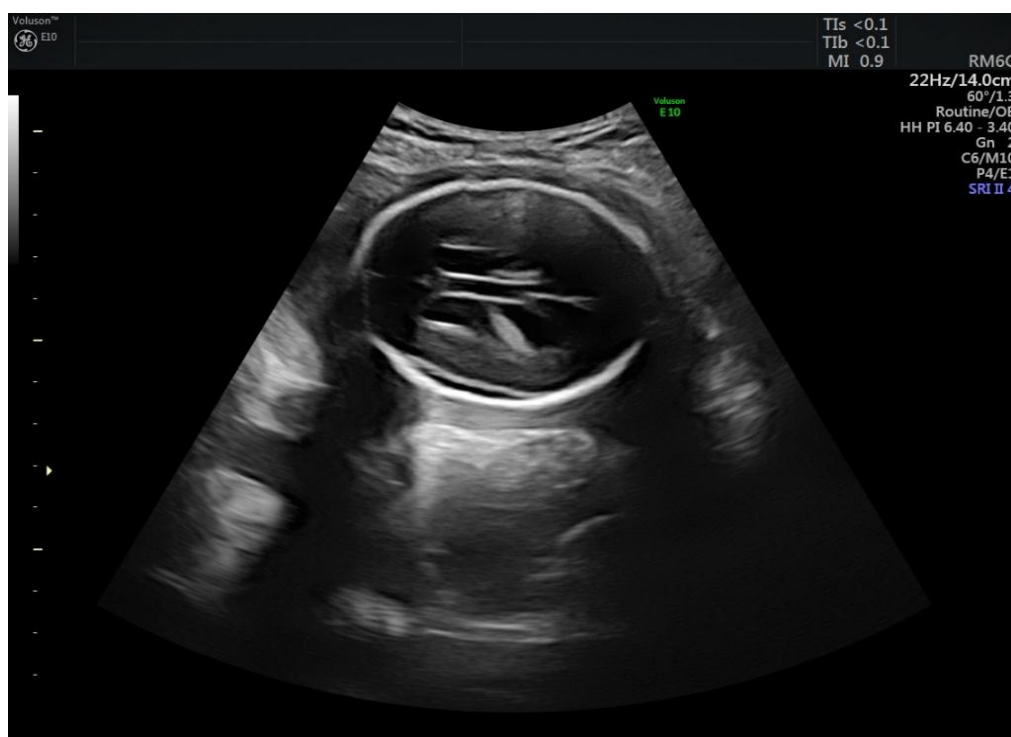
2D Ultrasound examination: Agenesis of corpus callosum.
